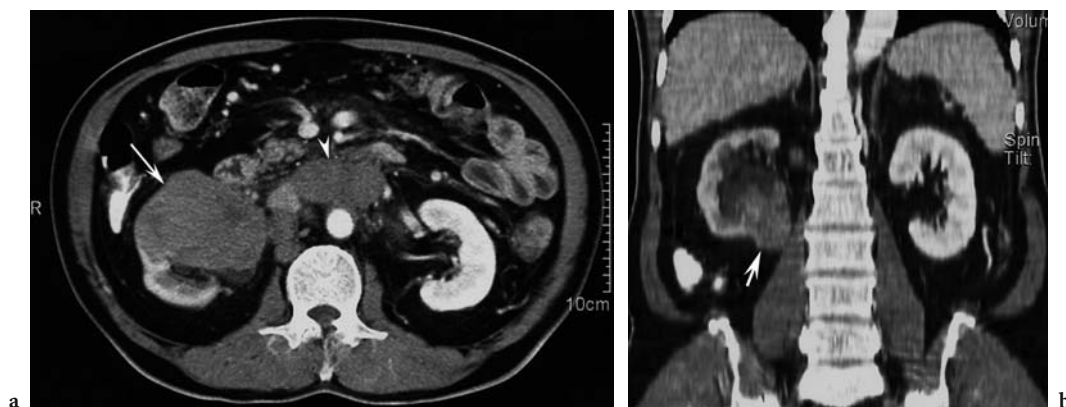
Lymphoma involving the renal parenchyma and renal sinus in a 56-year-old man with generalized weakness. a Axial contrast-enhanced CT scan shows a large relatively homogeneous mass (*arrow*) involving the right renal parenchyma and renal sinus. Note the multiple enlarged retroperitoneal lymph nodes (*arrowhead*). b Coronal reformatted CT scan obtained during the nephrographic phase shows the extent of the lymphoma mass (*arrow*) and mild hydronephrosis of the right kidney. (With permission from RHA et al. 2004)
